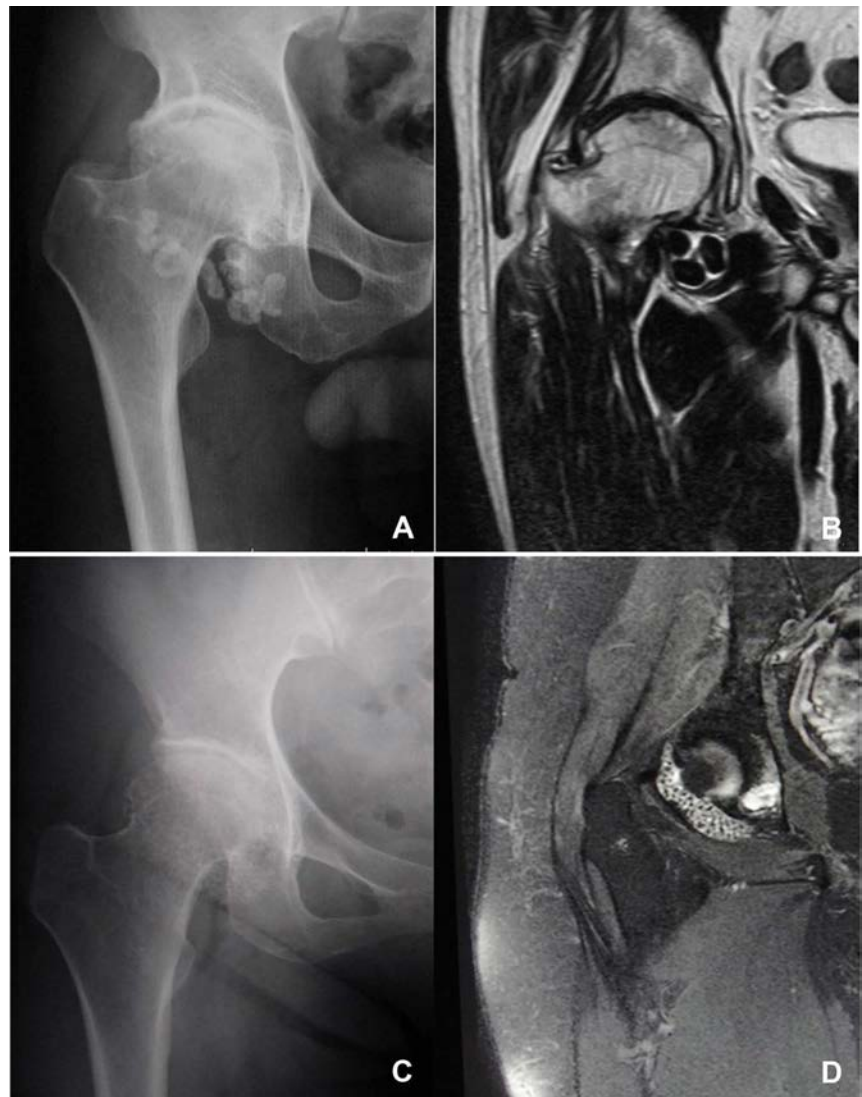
Primary synovial chondromatosis of the right hip in a 58-year-old woman (A,B) and in a 57-year-old man (C,D). A) Preoperative anterior-posterior radiographs demonstrates multiple calcified nodules filling around the femoral neck and joint-space narrowing the right hip joint. B) T2-weighted magnetic resonance indicates the presence of synovial thickening and multiple loose bodies with low signal intensity around the femoral neck and inferomedial portion of the capsular sac. C) Preoperative anterior-posterior radiographs indicates indistinct calcification and slight joint-space narrowing the right hip joint. D) T2-weighted magnetic resonance shows the presence of synovial proliferation and configuration of intra-articular bodies.
